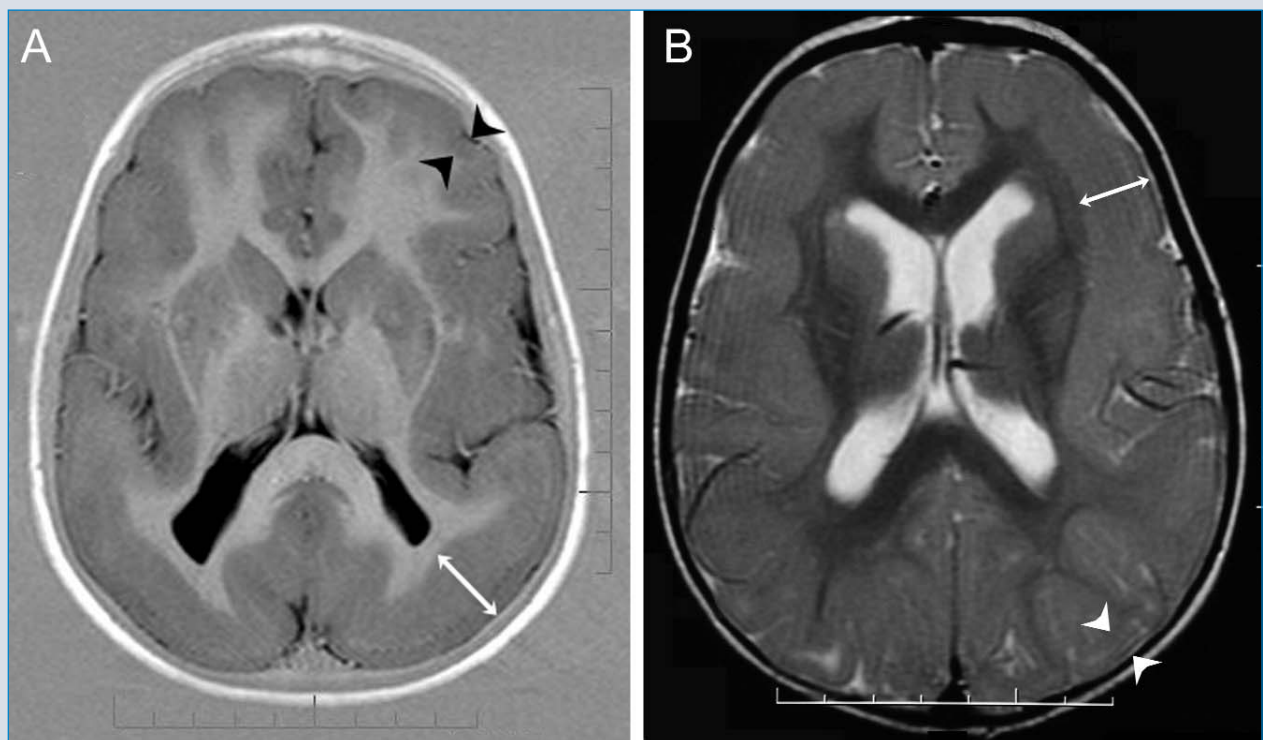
(A) Brain MRI scan; axial section: classical lissencephaly in a boy with LIS1 gene mutation. There is a typical posterior > anterior malformative pattern with relative preservation of the gyral pattern and cortical thickness in the anterior brain; cortical thickness is around 6 mm in the frontal lobes (black arrows; normal cortical thickness = 4 mm) and around 3 mm in the posterior brain (white arrow). (B) Brain MRI scan; axial section: lissencephaly in a girl with DCX mutation. There is a typical anterior > posterior malformative pattern, cortical thickness is around 2 mm in the frontal lobes (single white arrow) and around 4 mm in the posterior brain (double white arrows).
